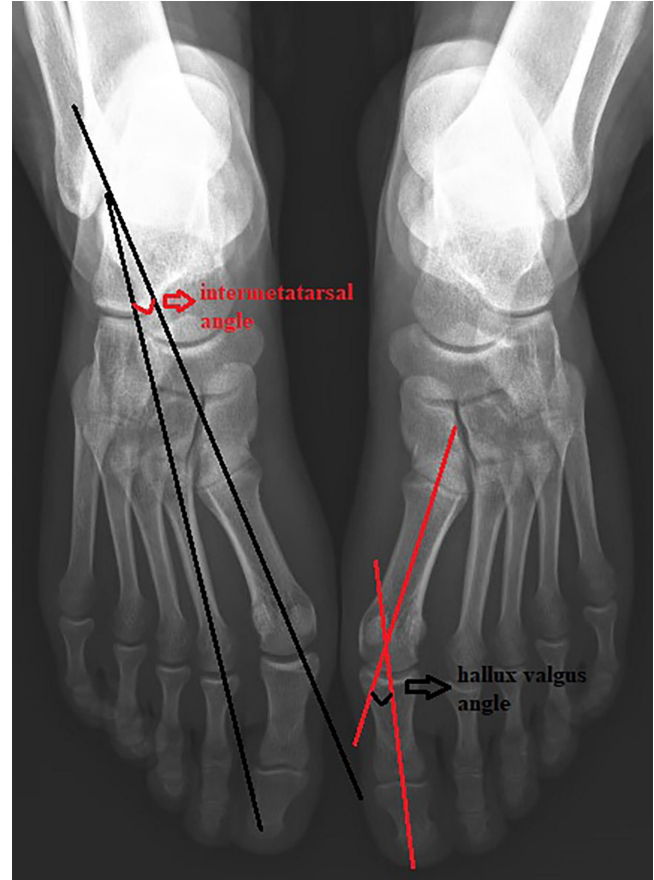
Measurement of the hallux valgus angle between the axis of the metatarsal bone and the proximal phalanx of the great toe.³⁶ The intermetatarsal angle is determined by measuring the angle between the long axis of the shafts of the first and second metatarsal bones on anteroposterior foot radiographs.³⁶ Hallux valgus can be categorized as mild, moderate, or severe. A mild hallux valgus deformity is defined as having a hallux valgus angle of $<20^\circ$ and a first intermetatarsal angle of $\leq 11^\circ$. A moderate deformity is defined as a hallux valgus angle of 20° - 40° and a first intermetatarsal angle $<16^\circ$. Severe deformity is characterized by a hallux valgus angle $>40^\circ$ and a first intermetatarsal angle of $\geq 16^\circ$.¹⁷
